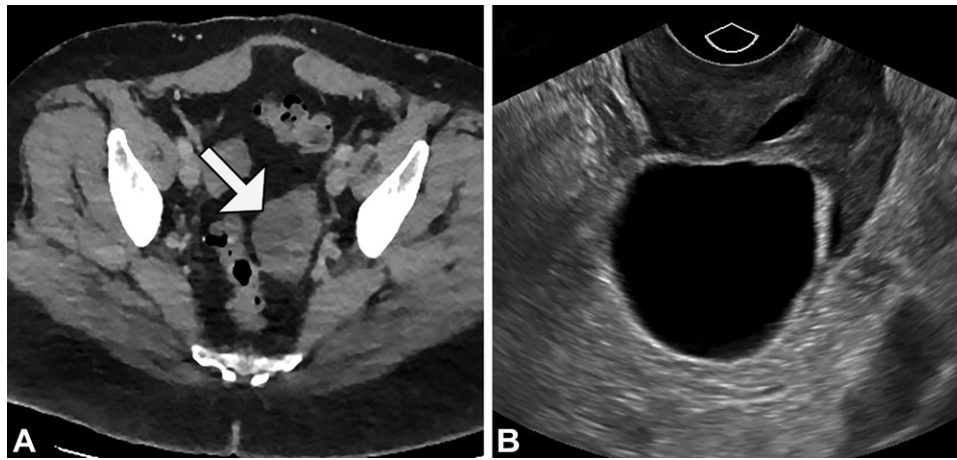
Cyst larger than 3 cm in a postmenopausal woman at CT that requires follow-up. (A) Axial CT image shows a 4-cm left ovarian cystic mass of 15 HU (arrow). The margins of the mass are difficult to characterize owing to technical limitations from poor signal-to-noise ratio secondary to body habitus. (B) Follow-up US image obtained 6 months later confirms stability of a simple anechoic cyst.
